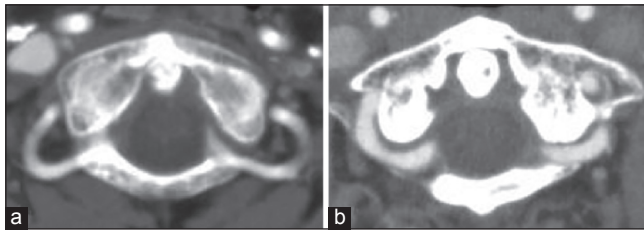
Axial computed tomography angiography (CTA) in Case 1 (a) showing posterolateral protrusion of bilateral vertebral artery (VA), which was differentiated compared to CTA in a different patient (b), whose bilateral VA was contained in the groove of the posterior arch of the atlas
